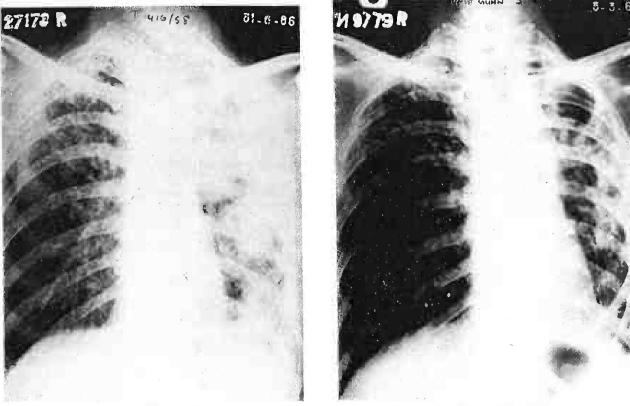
Before treatment. Fig. 5. After 9 months of treatment. Radiographs of a 42 year old patient showing clearing of lesions after treatment. Sputum converted.
